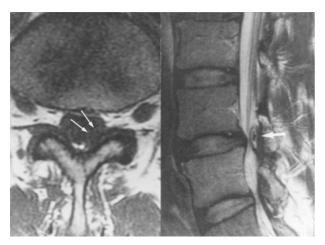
A magnetic resonance image (left: axial view, repetition-time, 400 msec; echo-time, 22 msec, right: sagittal view, repetition-time, 4000 msec; echo-time, 102 msec) revealed a T2 high intensity mass with a T2 low intensity core in the left L4-L5 ligamentum flavum (arrows)
